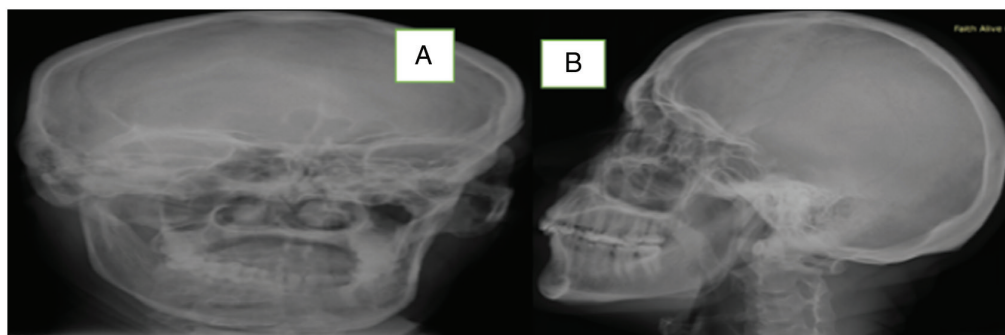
Plain skull X-ray; AP (A) and lateral (B) showing an ill-defined right orbital mass with distinct orbital lines
